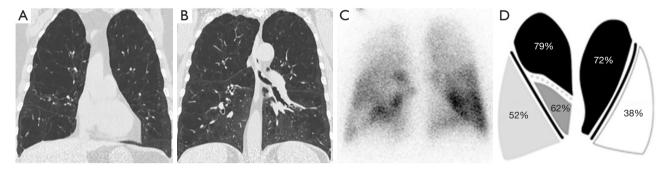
Images of an EBV candidate diagnosed with COPD. These images show severe, bilateral, upper-lobe predominant emphysema with complete major fissures. (A,B) The HRCT images show upper-lobe predominant heterogeneous emphysematous zones. (C) The perfusion scintigraphy shows lower diffusion zones in upper zones. (D) The StratX<sup>®</sup> lung report shows higher emphysematous destruction percentages (at -910 HU) and fissure integrity in upper lobes. EBV, endobronchial valve; COPD, chronic obstructive pulmonary disease; HRCT, high-resolution computed tomography; StratX<sup>®</sup>, quantitative lung computed tomography; HU, Hounsfield units.
